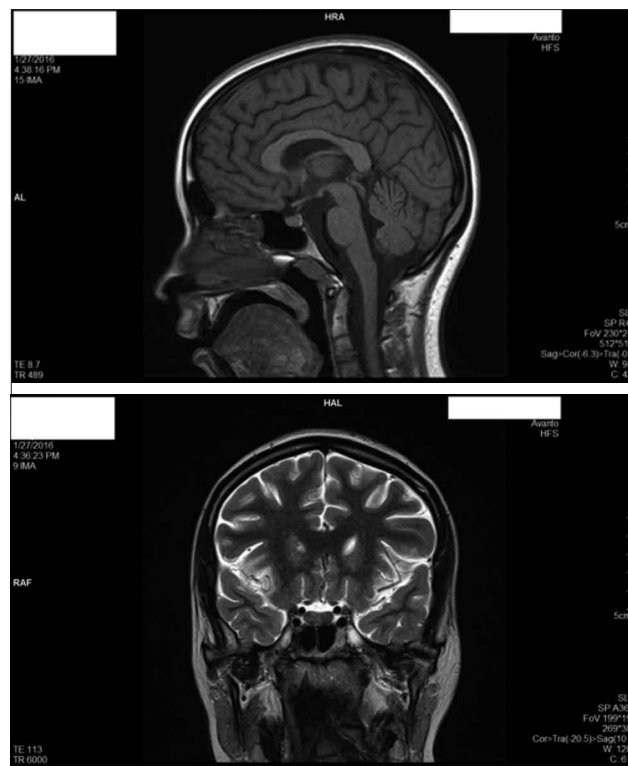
Brain MRI after 4 months of risperidone discontinuation.
